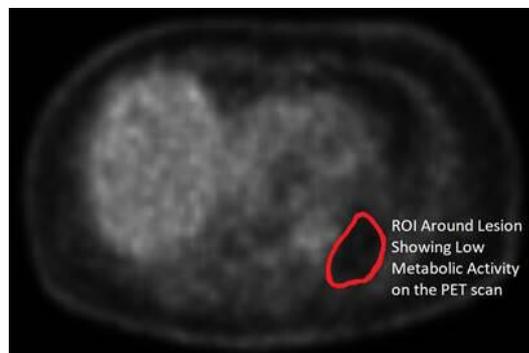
PET-CT scan showing mass with FDG avidity below the mediastinal pool. ROI highlighted to display the area of low metabolic activity. FDG, fludeoxyglucose; PET, positron emission tomography; ROI, region of interest
